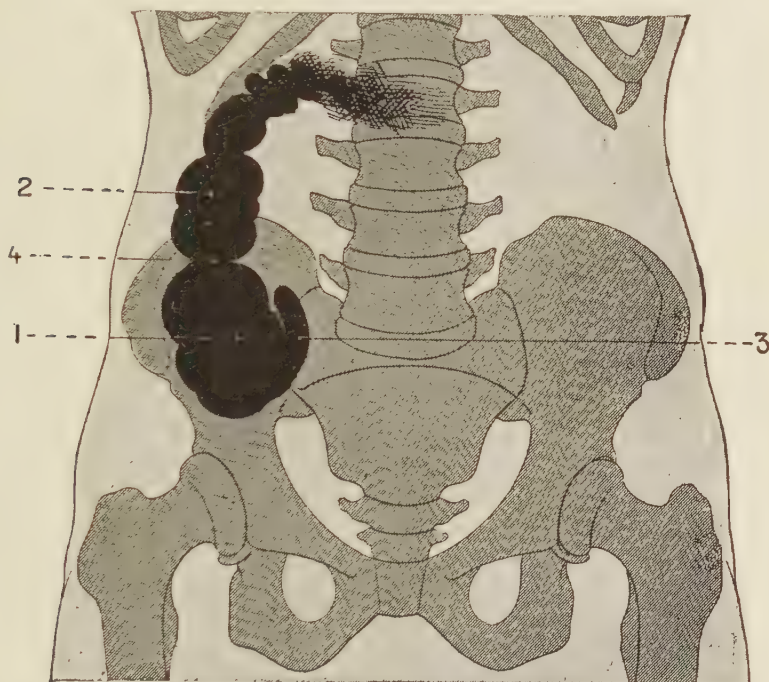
Radiographic picture of the cecum and appendix twelve hours after ingestion of bismuth magma. The cecum (1) and the ascending colon (2) appear dilated and segmented by the constricting bands due to pericolicitis. The appendix (3) is seen occupying a latero-internal position (*Bérard*).
